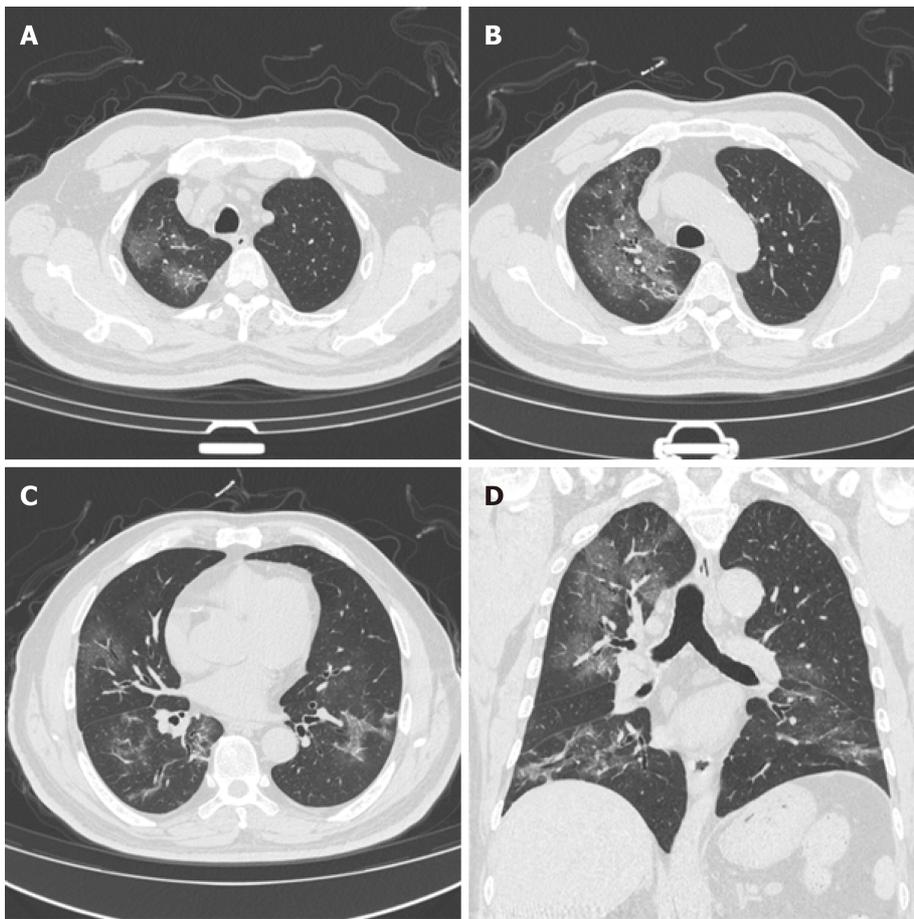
CT images from a 61-year-old male patient with a total lung score of 16 obtained 14 d after the onset of disease. A: A large ground glass density shadow of the right upper lobe; B: A large ground glass density of the right upper lobe with a small amount of flaky consolidation; C: A ground glass density shadow of the middle lobe of the right lung, paving-stone lesions of the lower lobe of the left lung, and a striped shadow in the lower lobe of both lungs; D: Coronal reconstruction images show a ground glass density shadow in the right upper lung. Both lower lungs are dominated by fibrous strips.
